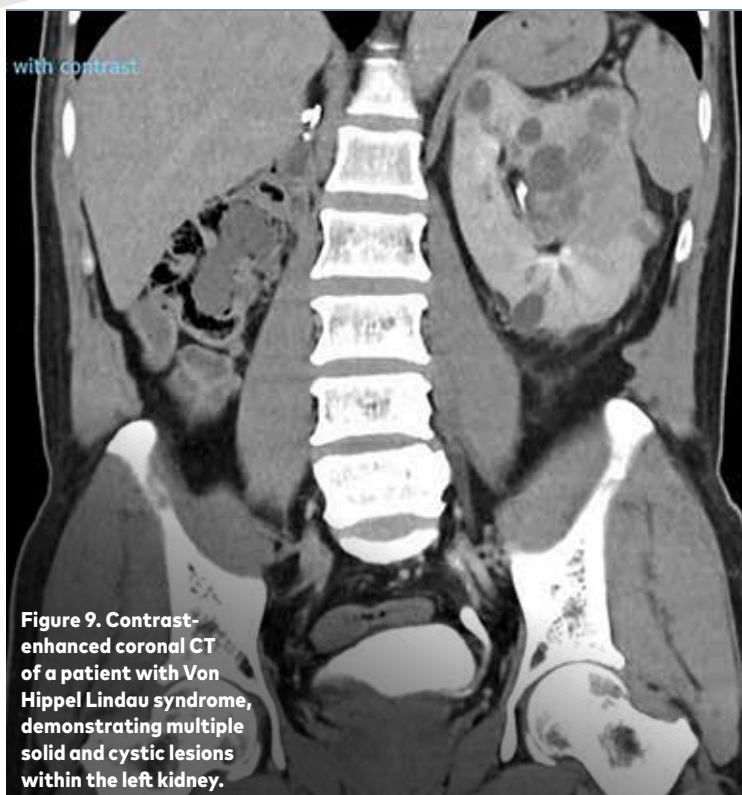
Contrast-enhanced coronal CT of a patient with Von Hippel Lindau syndrome, demonstrating multiple solid and cystic lesions within the left kidney.
